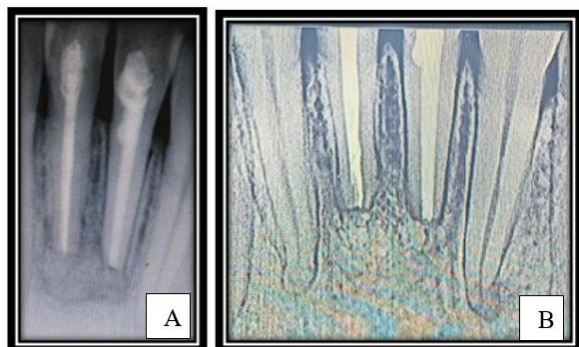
A) Radiograph after 1 month. Periapical defect filled with Bio-oss graft, B) Radiograph after 6 months.
